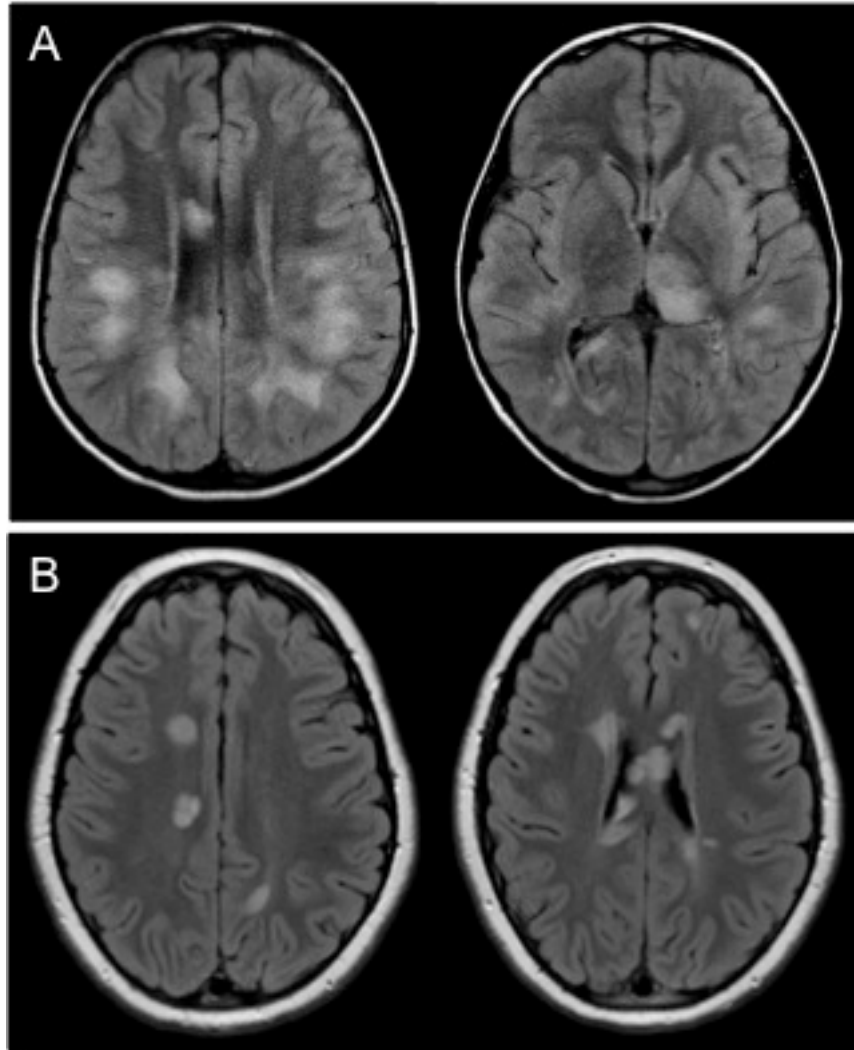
Axial FLAIR images acquired at onset in a child with monophasic ADEM (A) and a child diagnosed with MS (B). T2-weighted lesions in ADEM may appear larger and have hazy margins, compared with the focal lesions typically seen in patients with MS.
